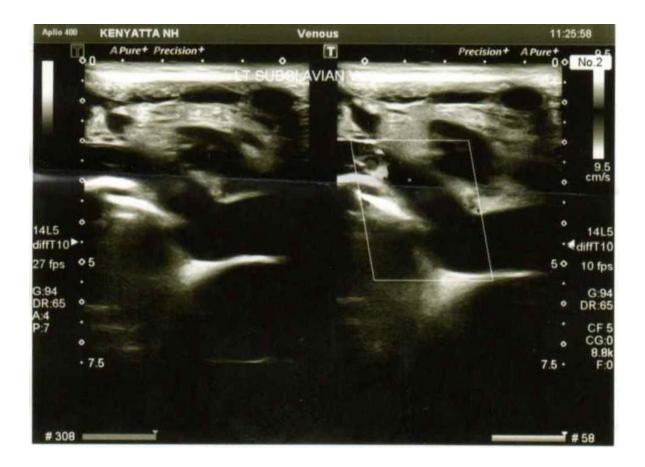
Grey scale and color doppler longitudinal scan of the right subclavian vein showing thrombus with no flow in that part.
